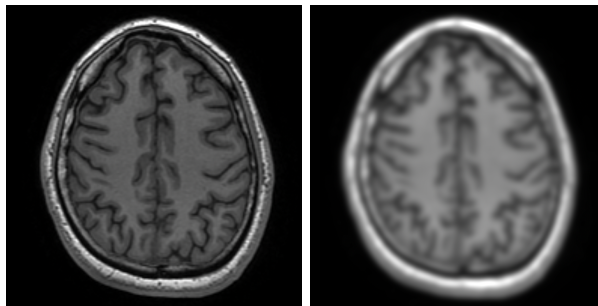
Comparison between the original MRI image (on the left) and the filtered MRI image (on the right).
